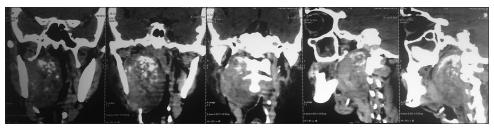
Computed tomography neck showing flakes of central calcification
